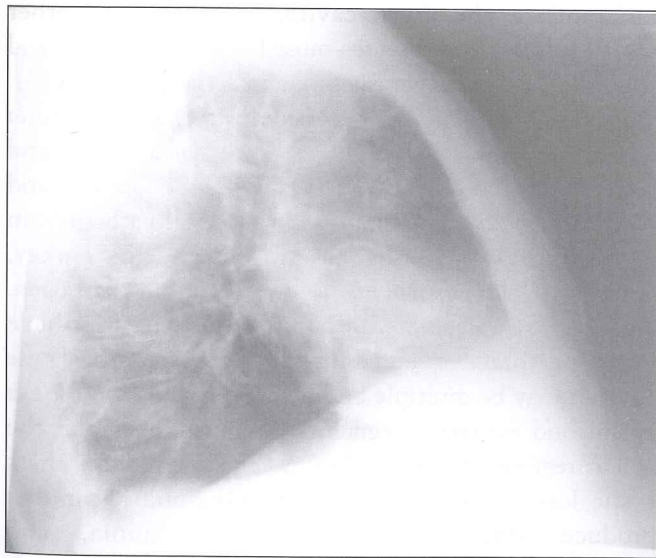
Lateral chest X-ray (2001)
